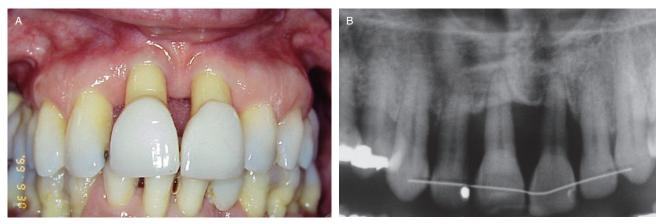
A*, Preoperative view of the patient demonstrated severe recession between the maxillary central and lateral incisors. *B*, Radiograph showed severe bone loss around central and lateral incisors.
